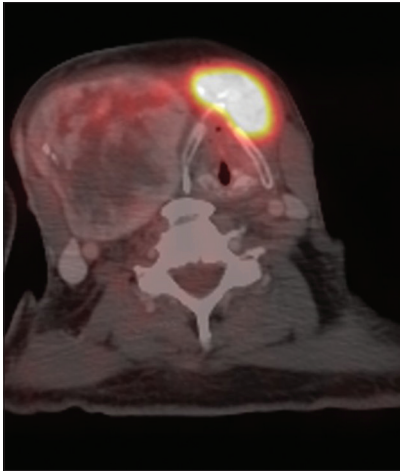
Axial section of follow-up positron emission tomography/computed tomography scan shows the partial regression of the metabolically active thyroid mass. The benign lesion in the right lobe of thyroid remains unchanged
